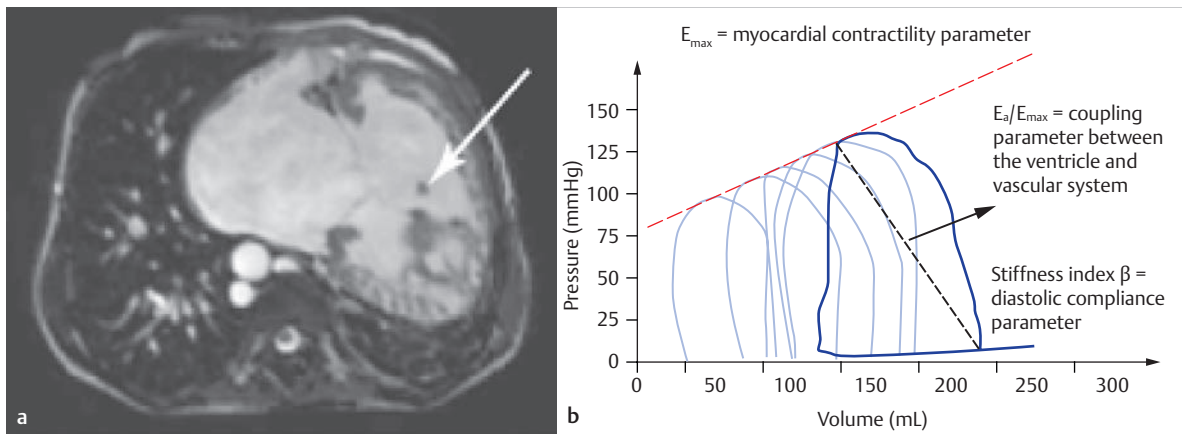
MRI-guided cardiac catheter exam with determination of the ventricular pressure-volume ratio.
